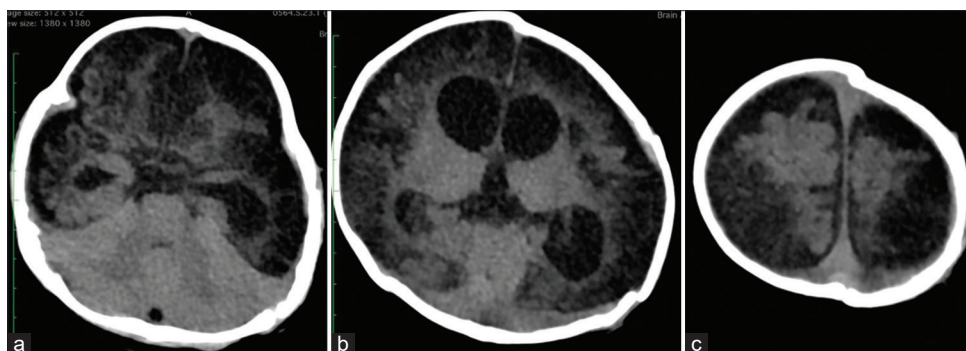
Post-operative non-contrast head computed tomography scan two months following surgery. (a) There was an extensive hypodense lesion on the cortical region, as well as dilatation of the temporal horn (b) The extensive hypodense lesion on the cortical was also seen along with dilatation of the lateral ventricle. “Hinged” bone could be found on the left side. (c) The cortical hypodense lesion was also identified up to the vertex region, but relatively less than the preoperative finding.
